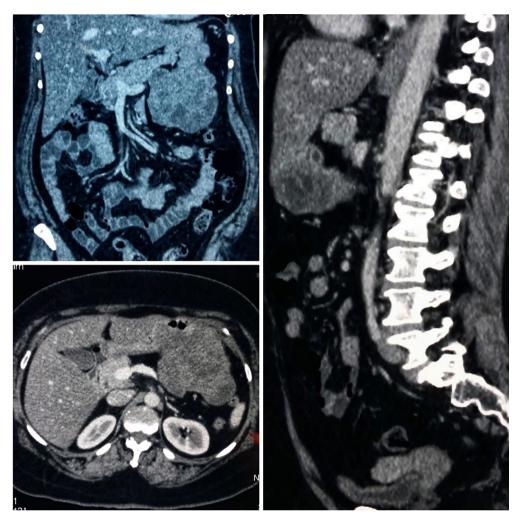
Computed tomography showing large exophytic mass in relation to stomach and pancreatic tail.
